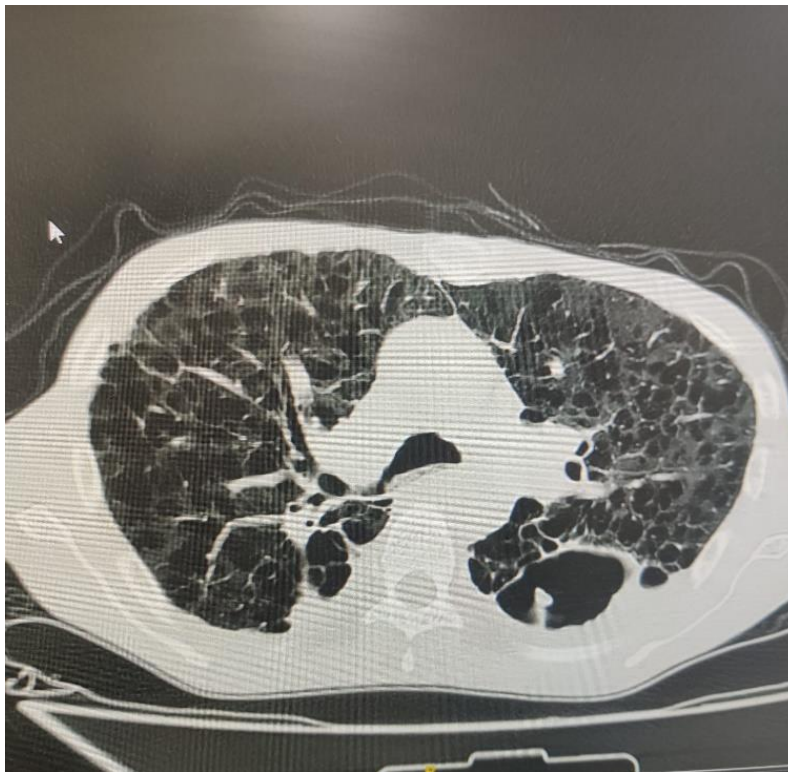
showing HRCT Thorax revealed cavity with internal soft tissue density area noted in apicoposterior segment of left upper lobe
